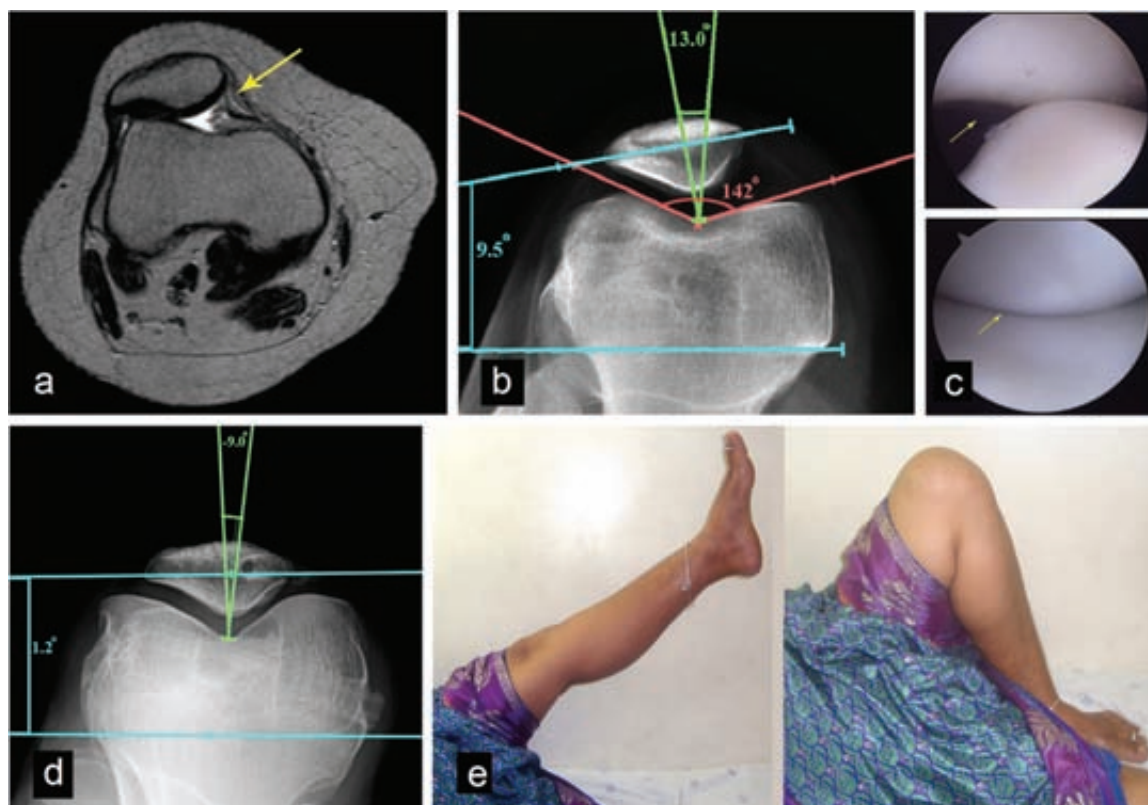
(a–e): Case example of a 38-year-old female with recurrent dislocation of patella. (a) Pre-operative MRI shows MPFL tear. (b) Pre-operative radiograph shows lateral subluxation with tilting of patella. (c) Intraoperative arthroscopy confirms abnormal patellar tracking which is restored to normal after MPFL reconstruction. (d) Post-operative radiograph shows restoration of normal patellar alignment. (e) Post-operative regain in full range of movements in the knee.
